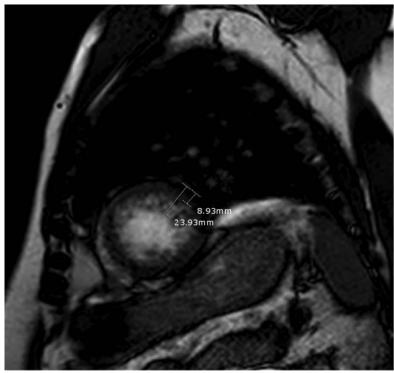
Cardiac MRI (CMR) views feature large diastolic myocardial ratio of noncompacted to compacted thickness, at the ED Short axis the NC/C ratio was calculated as greater than 2.3.
